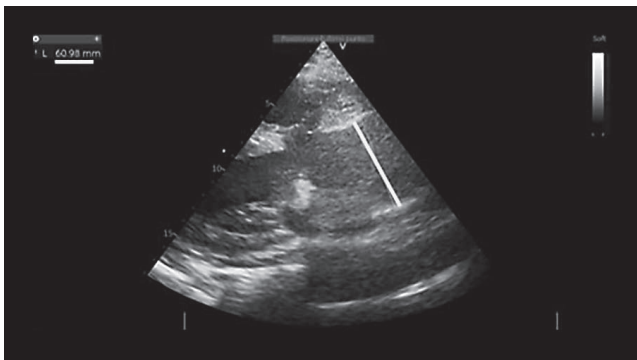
The transthoracic echocardiography showed the aortic aneurysm with a severe dilatation of the aortic root (about 61 mm).
